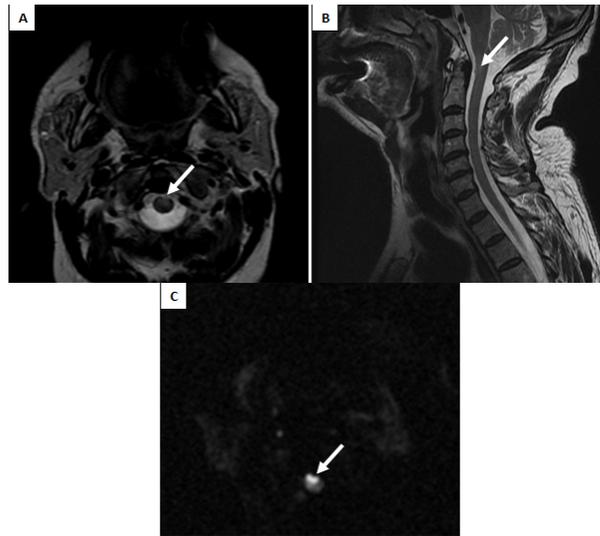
Spinal cord MRI: T2 FLAIR weighted sequences in axial (A) and sagittal (B) sections and diffusion sequence (C) shows Intramedullary signal abnormalities at the cervical level opposite C2 in T2 Flair hyper signal (A, B) with diffusion restriction giving the “Owl’s eye” appearance (C).
